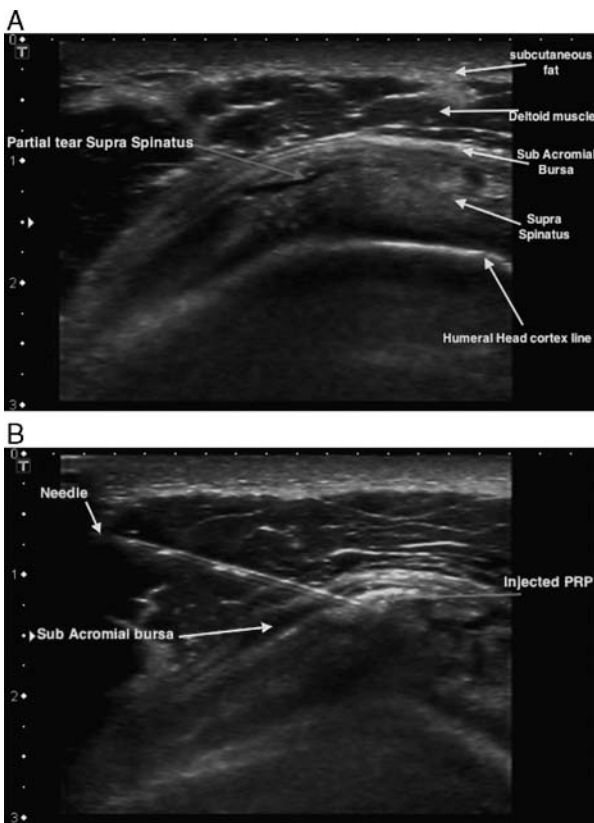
A, An axial ultrasound (US) picture of a supra spinatus partial tear (red arrow). Orange arrows are pointing at the anatomic landmarks of the region. The hypoechoic/black appearance of the tendons and muscles, especially in the left side periphery of the pictures is the result of the anisotropic phenomena, an US artifact, and a good example why US is very operator dependent. B, An axial US picture of a supra spinatus partial tear during its injection with PRP, seen as the white/hyperechoic area marked with red arrow. The PRP is now filling the tear within the tendon and starts to spread out into the subacromial to subdeltoid bursa along its plane, covering the supra spinatus.
